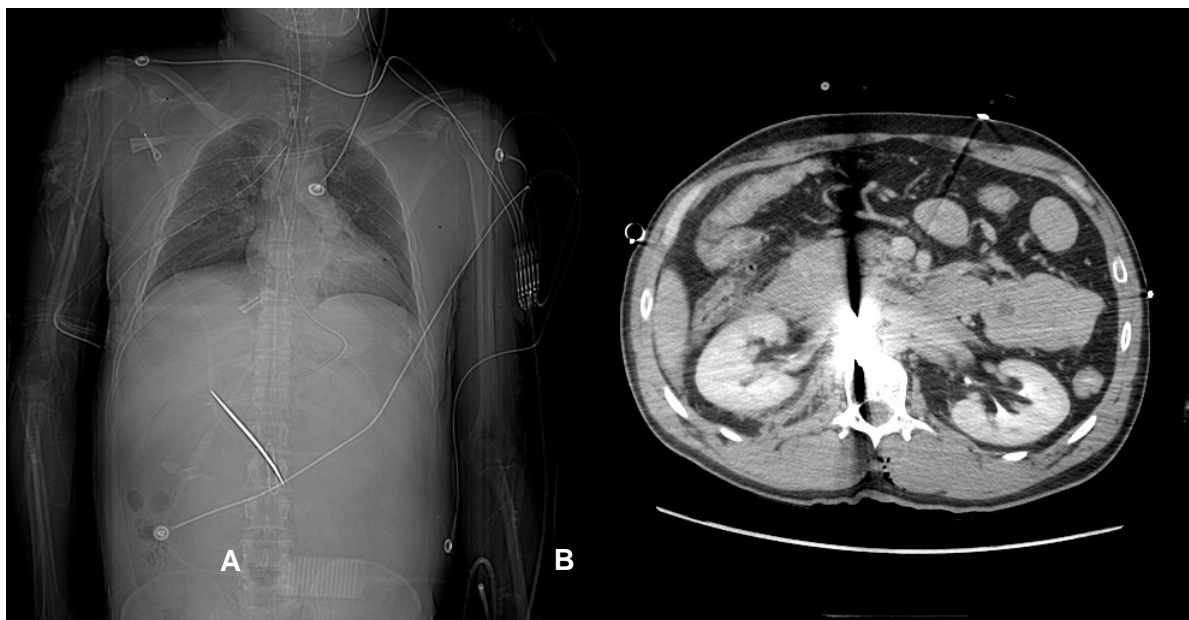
A) Scout film demonstrating retained knife blade. B) computed tomography demonstrating the retained knife blade and resulting artifact.
